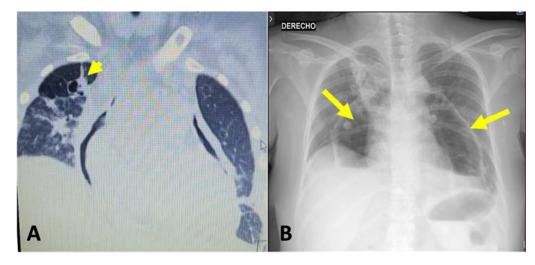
A: Chest CT scan in a : Pulmonary cavity in tight upper lobe (arrow); B: Chest X-ray: Hydrneumopericardium (arrows).
